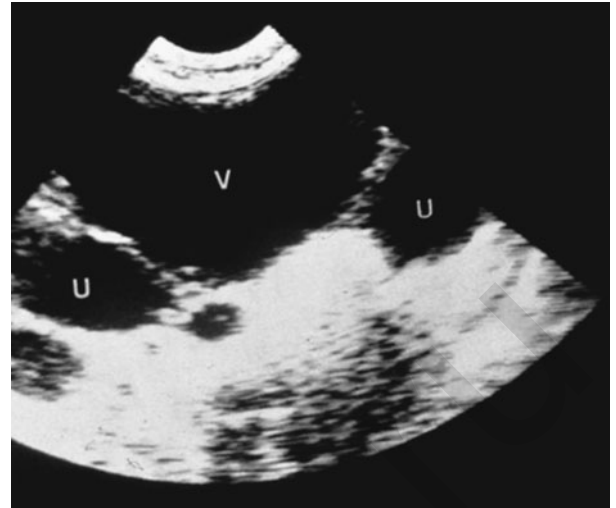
Ultrasonographic findings in an infant with posterior urethral valves: bilateral hydronephrosis, enlarged ureters with distended bladder.
